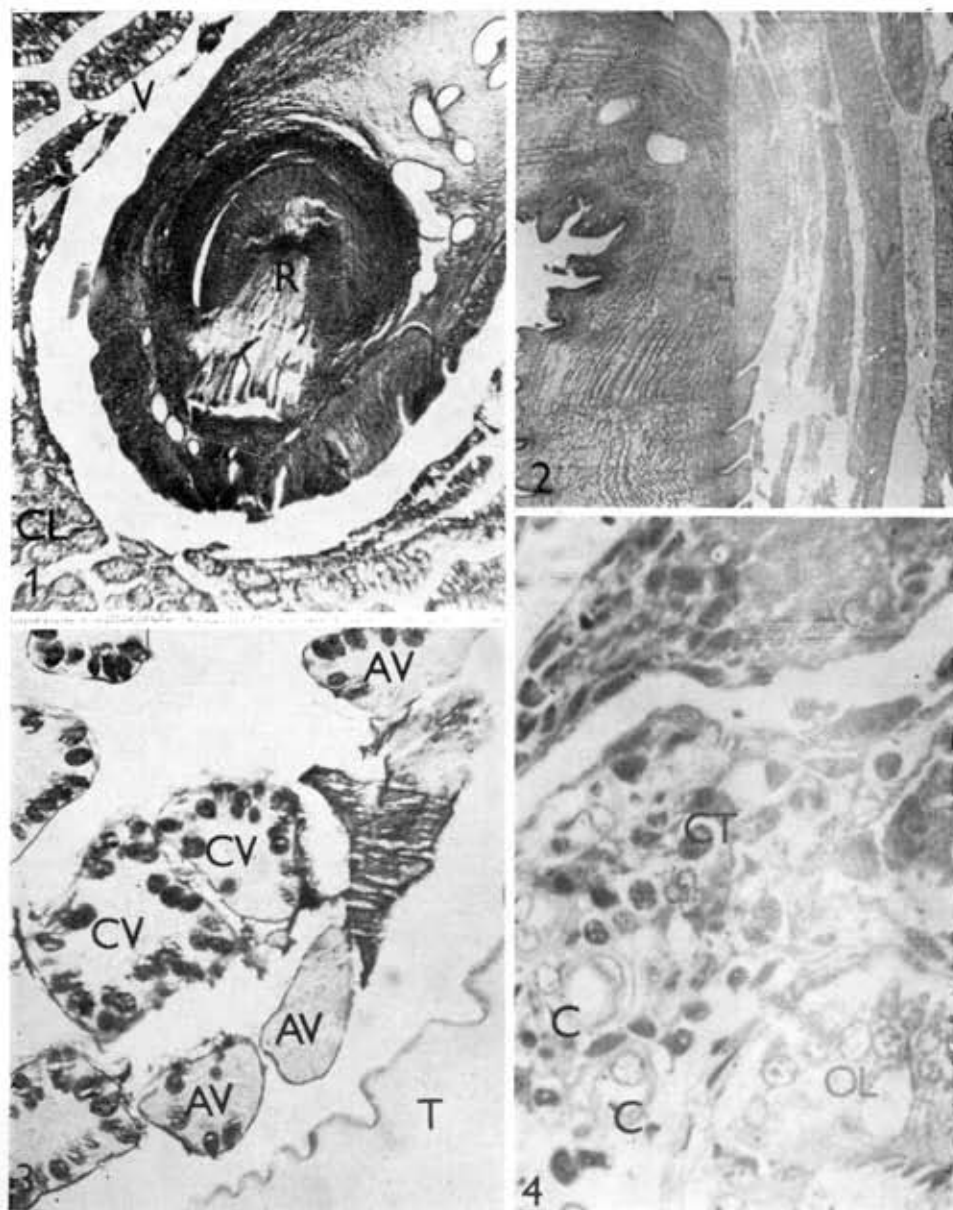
Oblique section through scolex with invaginated rostellum (R) penetrating through villi (V) into middle parts of the layer of Lieberkühn's crypts (CL). Trichrome after Masson ($\times 7.0$). Fig. 2. Part of strobila (T) among villi of intestinal mucosa (V). Conspicuous compressive (pressure) atrophy of adjoining villi. Mallory ($\times 55$). Fig. 3. Transverse section through villi of intestinal mucosa (CV) near strobila (T). Mucus production ceases in atrophied hypo- to nonfunctional villi (AV). Lugol-aldehyde fuchsin reaction ($\times 220$). Fig. 4. Detail of edema and inflammatory infiltration of connective tissue (CT) among Lieberkühn's crypts (OL). Capillaries (C), residue of atrophied crypt (AC). Semi-thin section, toluidine blue ($\times 660$).
